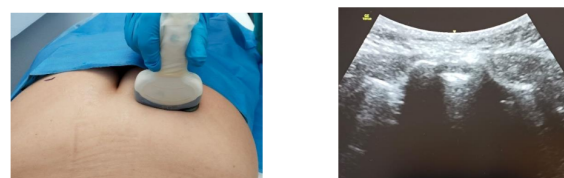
Ultrasound research of the sacral hiatus
